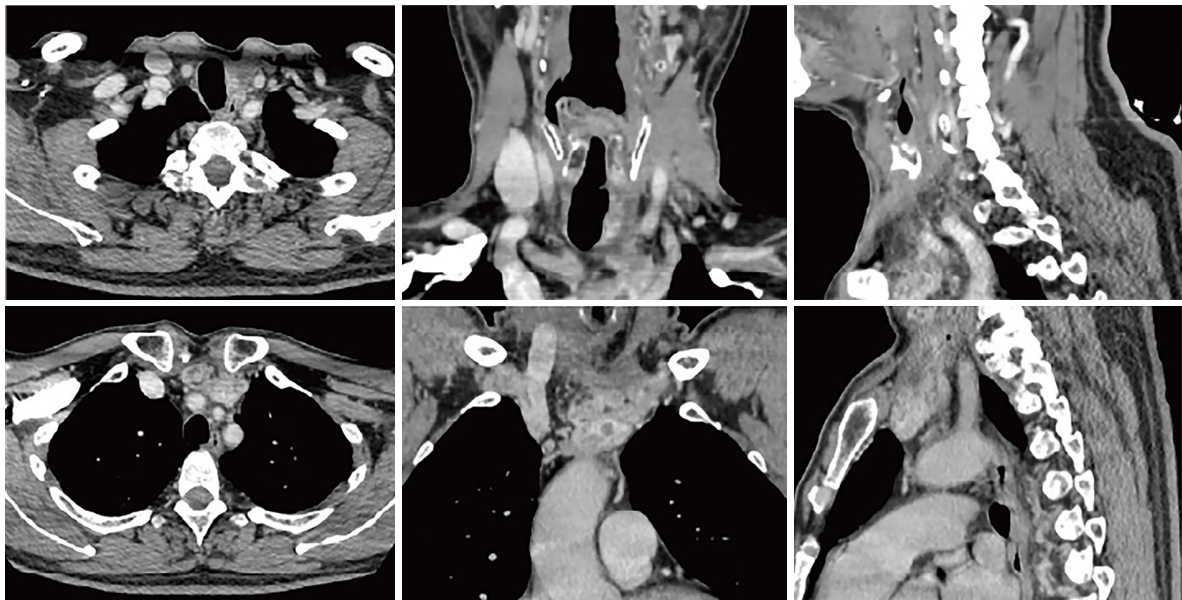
Contrast-enhanced CT images at 4 months after the first RAIT. CT, computed tomography; RAIT, radioactive iodine therapy.
